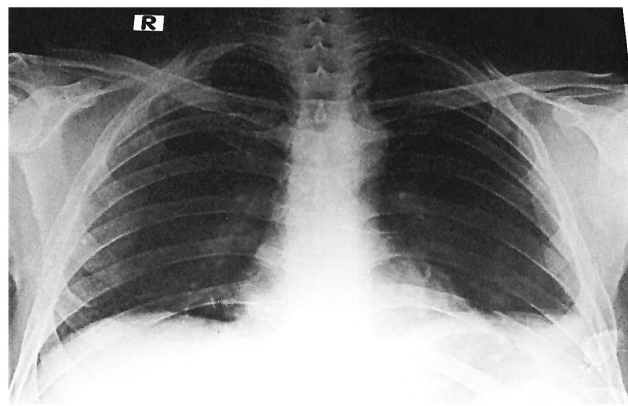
Chest X-ray showing the presence of left-sided pleural reaction.
